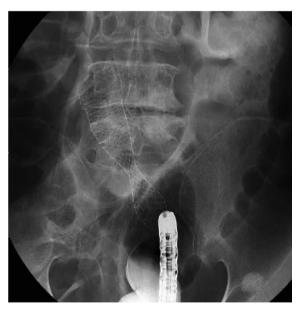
Postoperative radiograph in a patient who underwent self-expanding metal stent insertion as palliative treatment for malignant colorectal obstruction. The stenosing lesion was stented via a combined endoscopic and fluoroscopic approach.
